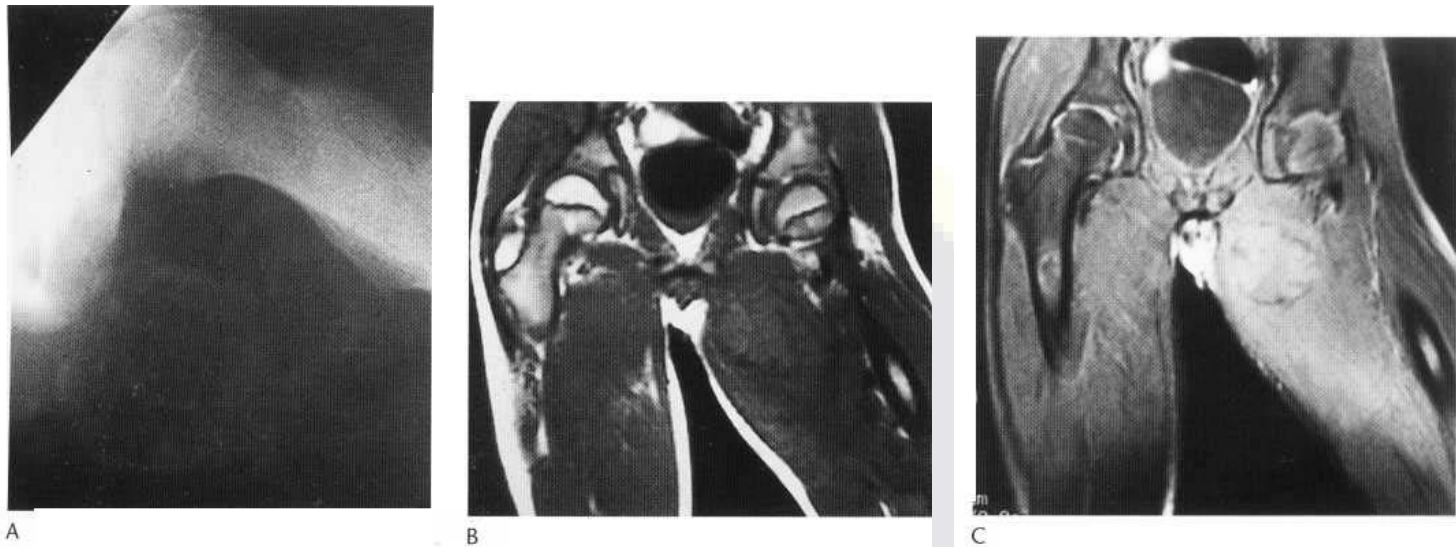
(A) A calcified 'mass' in the thigh of this 16 year old was worked to exclude tumour. (B) T₁-weighted coronal MR images demonstrate a mass of low signal intensity, with surrounding low-signal-intensity oedema, with increased signal intensity on T₂-weighted images (C). There is also a well-defined, low-signal-intensity 'ring' of calcification. Their appearances are characteristic of post-traumatic myositis ossificans.
